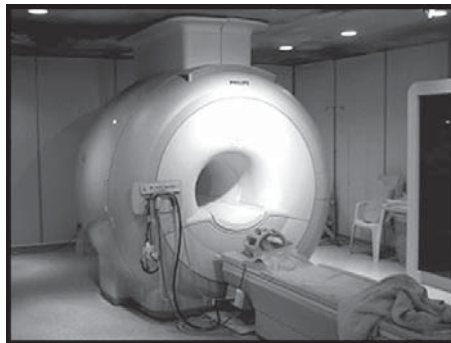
Modern 3 Tesla Clinical MRI Scanner.
